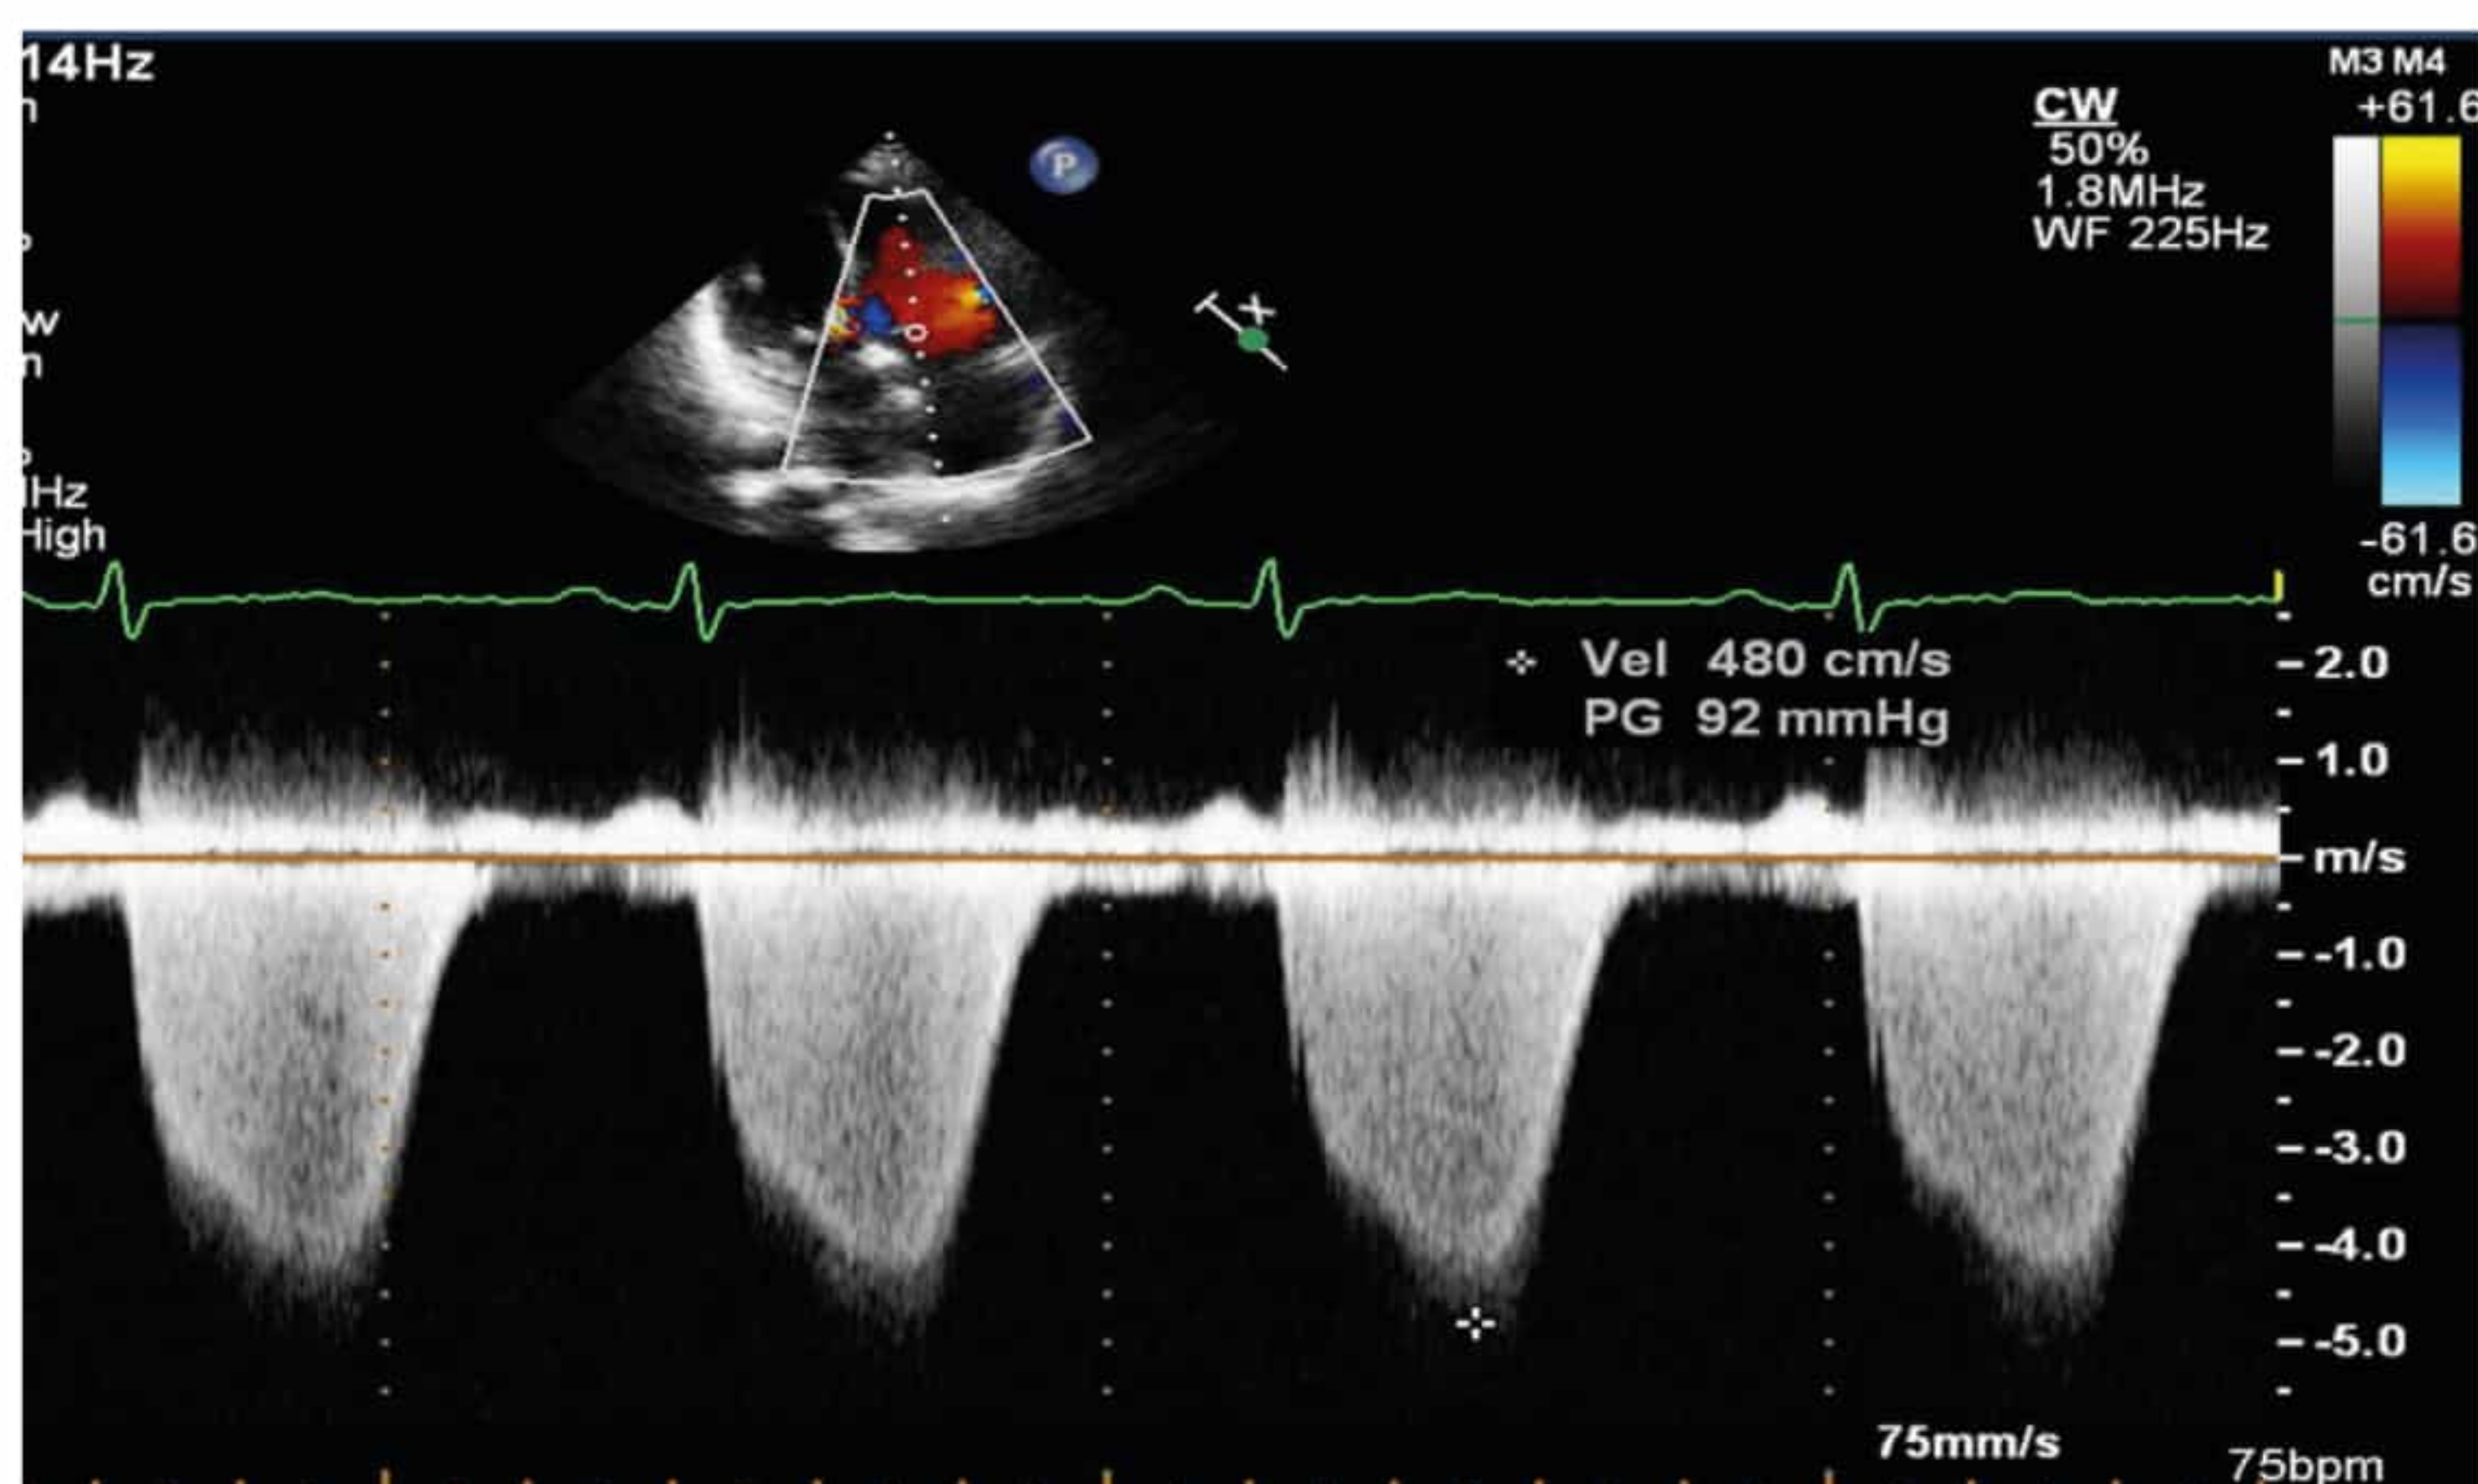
Doppler echocardiographic determination of systolic pulmonary artery pressure (SPAP). Spectral continuous-wave Doppler signal of tricuspid regurgitation (TR) jet is used to derive the SPAP. The TR jet velocity indicates the right ventricular (RV) – right atrial (RA) pressure gradient. The SPAP is derived as the sum of the estimated RA pressure (RAP) and the peak pressure gradient between the peak right ventricle and the right atrium, as estimated by application of the modified Bernoulli equation ($4 V^2$ where V is the velocity of the TR jet) to peak velocity represented by the tricuspid regurgitation Doppler signal.⁹ The RAP was estimated from the inferior vena cava diameter. If the IVC was ≤ 21 mm and the deep inspiratory collapse (“sniff test”) was >50%, RAP was estimated to be 3 mmHg; if the diameter was >21 mm and the collapse <50%, RAP was estimated as 15 mmHg; in intermediate cases, a value of 8 mmHg was assigned.⁹ In this example, SPAP is estimated at 92 + central venous pressure, or 100 mmHg, if RAP is assumed to be 8 mmHg.
